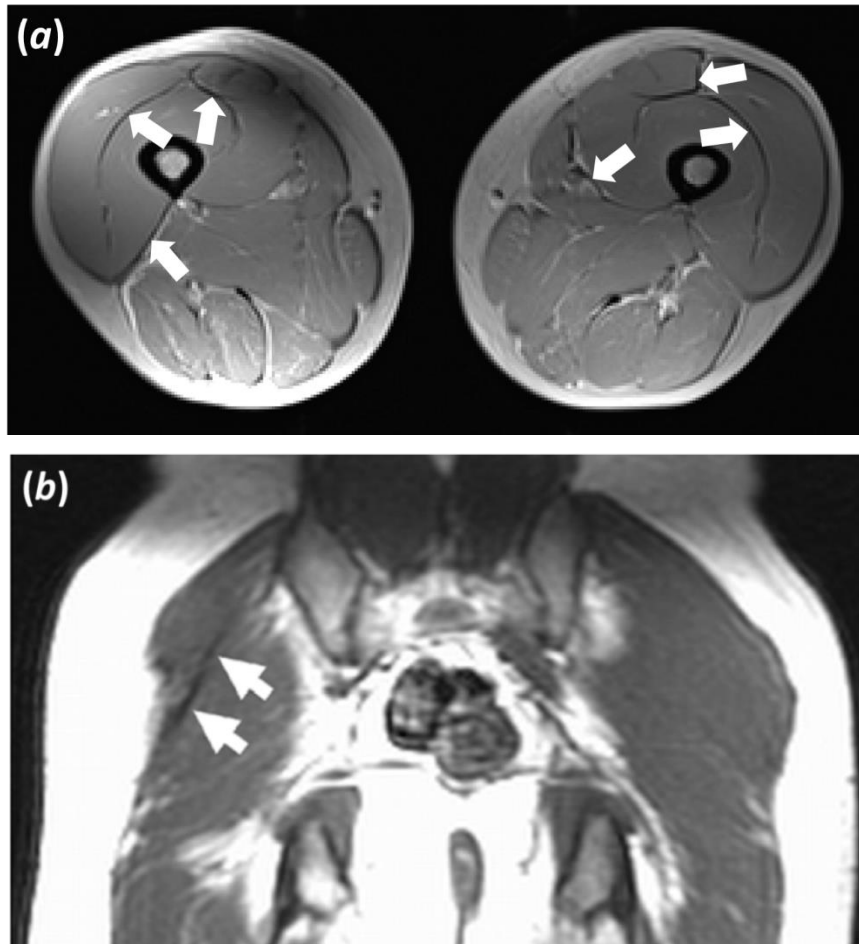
The hypo-signal of compact collagenous tissue structures observed in NMR images. (a) Spin-echo PD image ($TE = 9.5\text{ ms}$) of the thighs. The arrows point to the dark visible fascia with its characteristic hypo-signal. (b) Spin-echo T1-weighted image ($TE = 16\text{ ms}$) of both buttocks. The Arrows point to a dark visible thin fibrotic cord in atrophic right gluteus maximus muscle. Normal left side may be used for comparison. Image in (b) was taken from (144).
